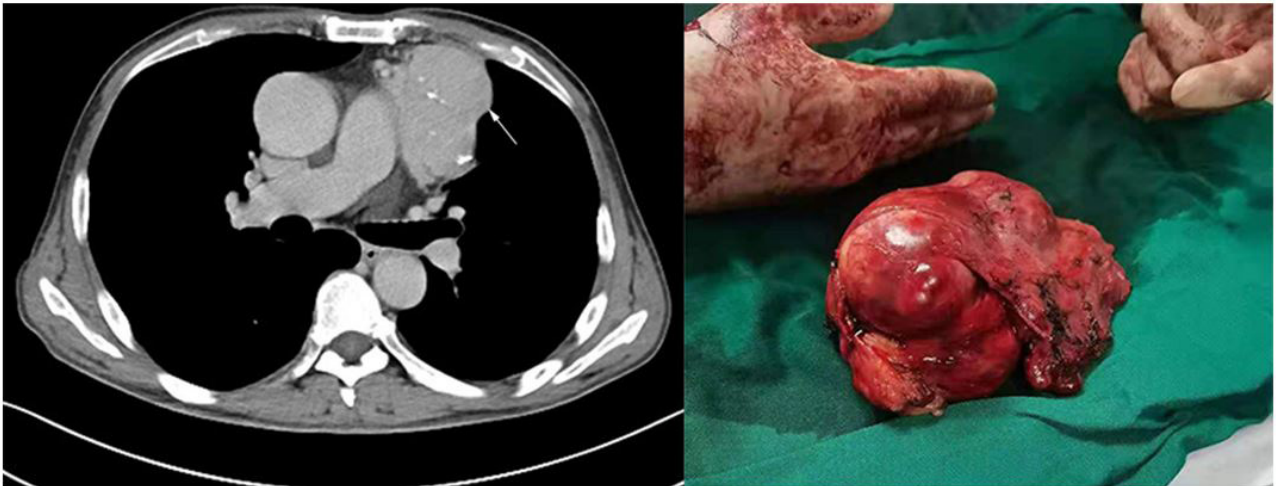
CT image and clinical picture of the mediastinal mass
